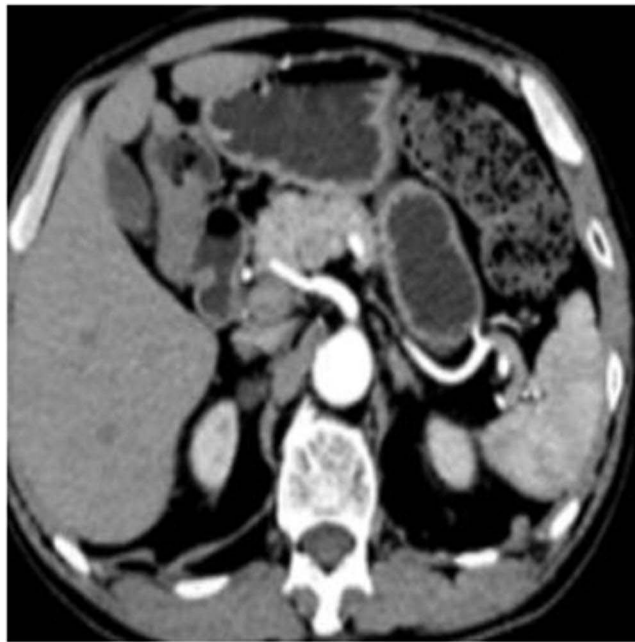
Initial computed tomography image showing no abnormalities in the abdomen.
